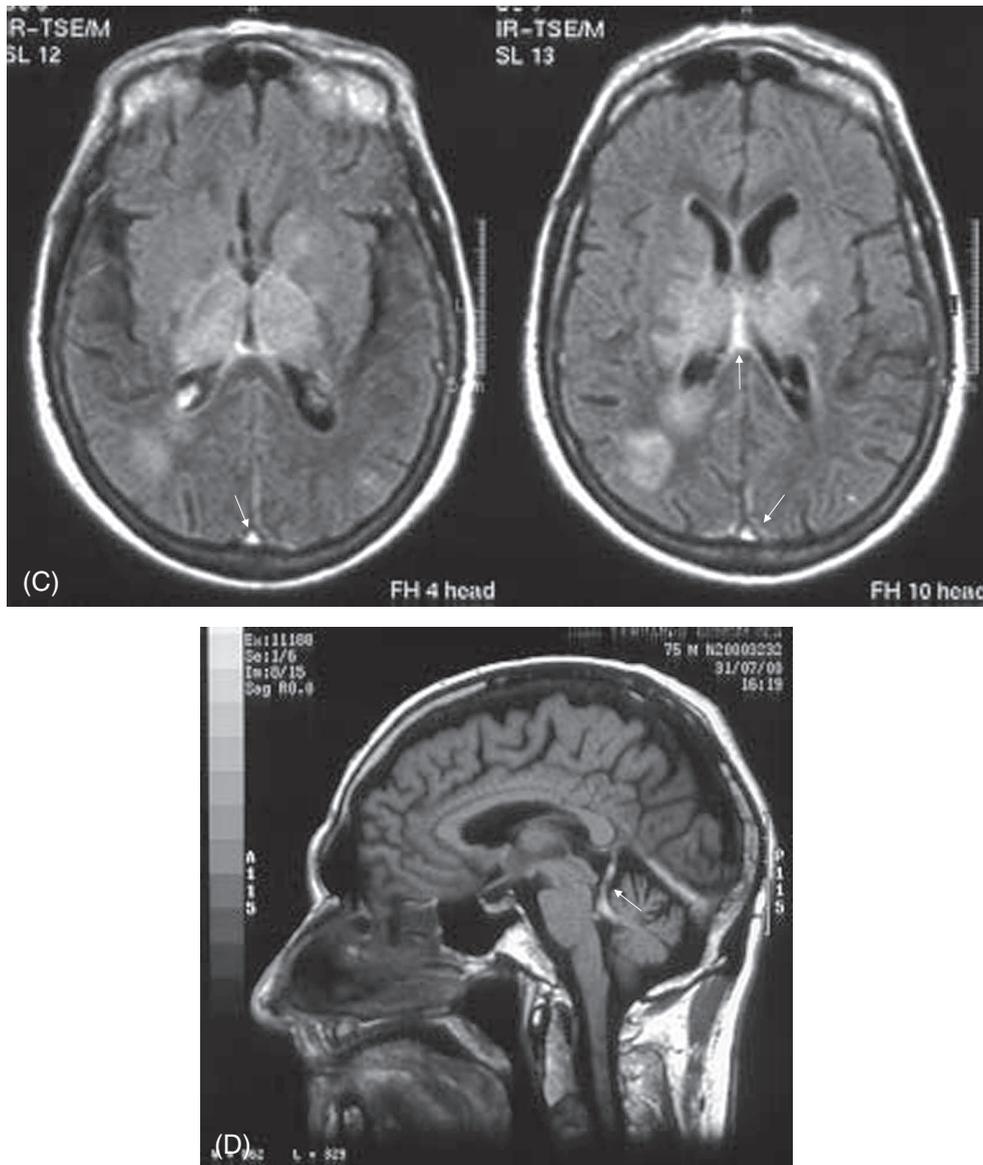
Cont'd. (C) T2-weighted MRI shows bilateral thalamic edema due to thrombosis of the deep cerebral venous system (hyperintense signal in arrows) and cortico-subcortical right parieto-occipital oedema. It also shows a thrombus in the superior sagittal sinus as a hyperintense signal. (D) T1-weighted MRI depicts hyperintense signal in the thrombosed superior cerebellar vein.
